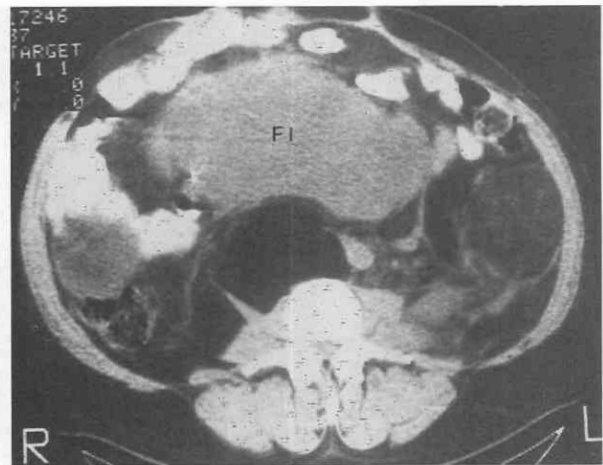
Liposarcoma. Nondynamically enhanced abdominal CT scan reveals a large area of fluid attenuation (FI) surrounded by fat.
